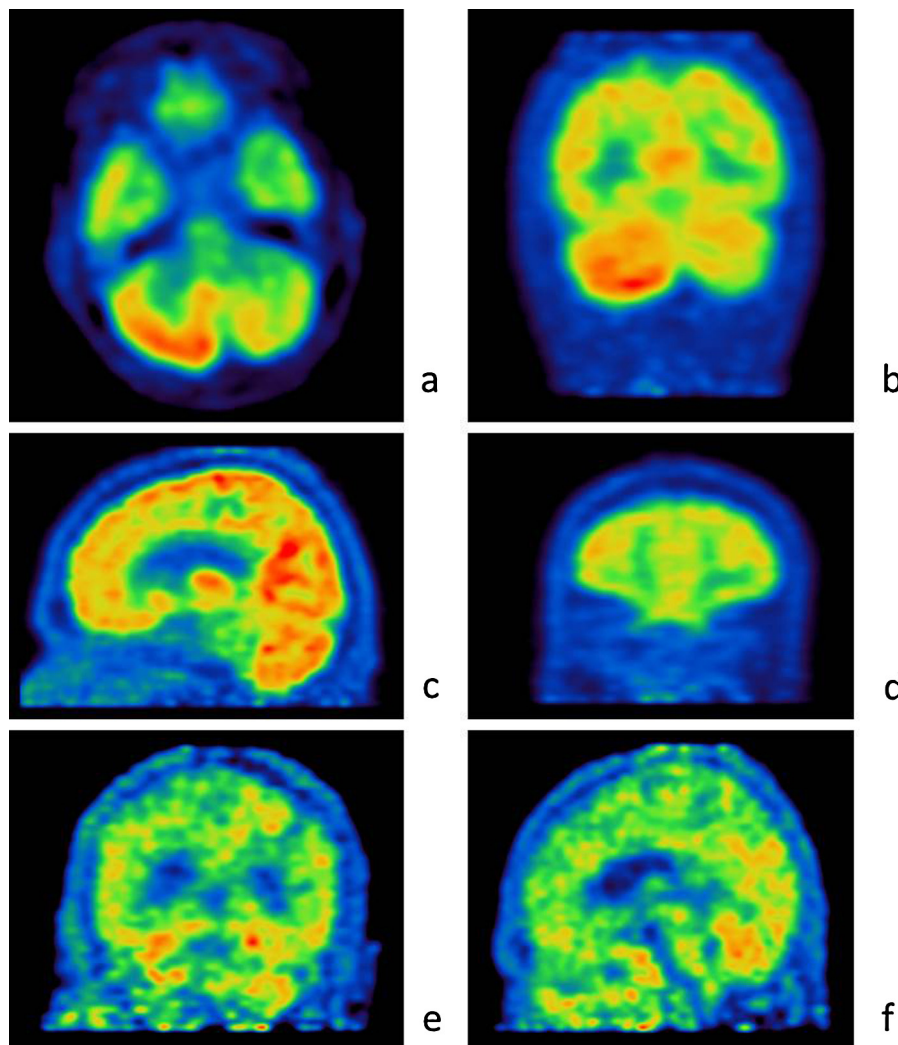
^{18}F -FDG PET/CT scans: (a, b) 25 year old patient suffering TBE with region of glucose hypermetabolism to the right cerebellum, (c, d) 72 year old patient with a region of glucose hypometabolism including the frontal lobe on both sides and (e, f) 80 year old patient with global cerebral glucose hypometabolism, however, the patient was intubated and analgosedated previous to the scan.
